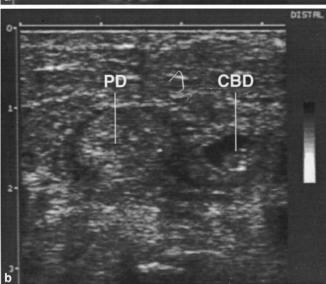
Laparoscopic ultrasound scans of a patient presenting with obstructive jaundice secondary to a periampullary tumor. a. This transverse scan through the head of the pancreas shows a prominent lower common bile duct (CBD) and pancreatic duct (PD), the second part of the duodenum (D2), and inferior vena cava (IVC). b. This image, which is proximal to the ampulla, demonstrates a tumor infiltrating the pancreatic duct and within the lumen of the lower common bile duct.
